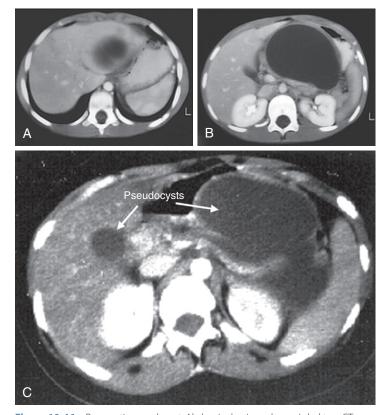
Pancreatic pseudocyst. Abdominal pain and emesis led to a CT scan in this patient, who had a bicycle handlebar injury 2 weeks earlier. A, Septation of the cavity. B, Compression of stomach and pancreas by the pancreatic pseudocyst. C, Two large pancreatic pseudocysts. *(Courtesy Mark Lowe, MD, Pittsburgh, Pa.)*
